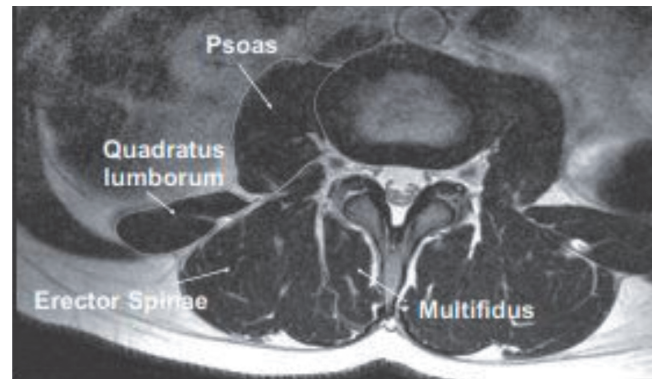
MRI of L3-L4 disc level showing paraspinal muscles around it.
